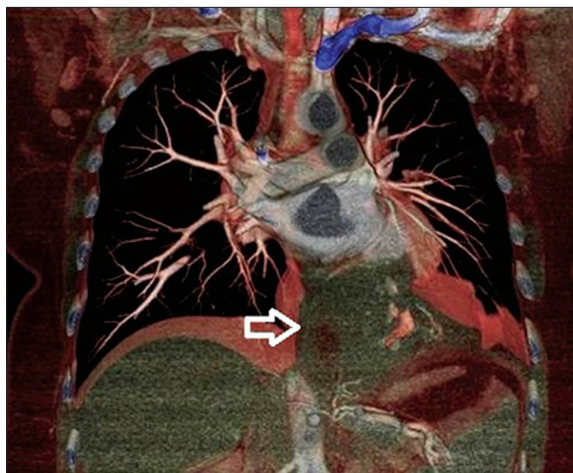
Coronal view of computed tomographic reconstruction showing the tumor in the left hemithorax (arrow indicates the tumor)
